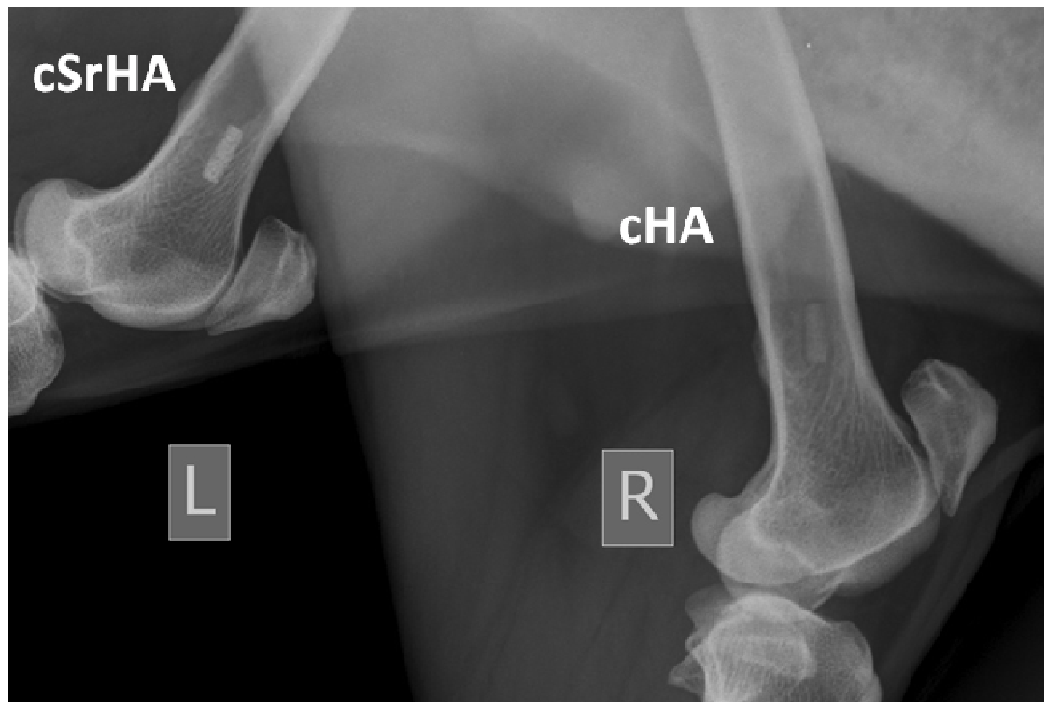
In vivo* radiopacity evaluation of the implants: Radiographs of cHA and cSrHA indicated the improved radiopacity of cSrHA scaffolds, post two months of implantation.
